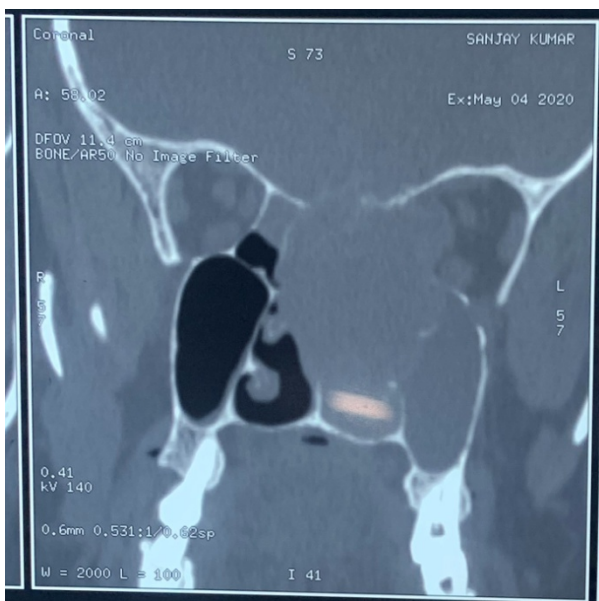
Pre operative CT scan of the paranasal sinuses – coronal view showing dumbbell shaped mass in the left nasal cavity with extensions into the anterior cranial fossa, orbit and paranasal sinuses. The ‘waist’ of the dumbbell is at the cribriform plate.
